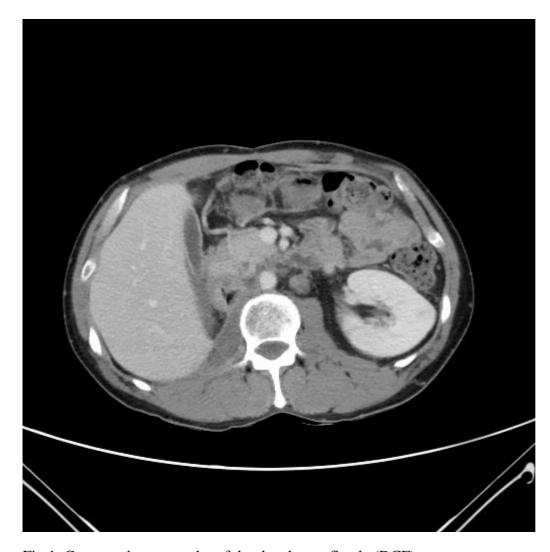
Computed tomography of duodenal cava fistula (DCF)
